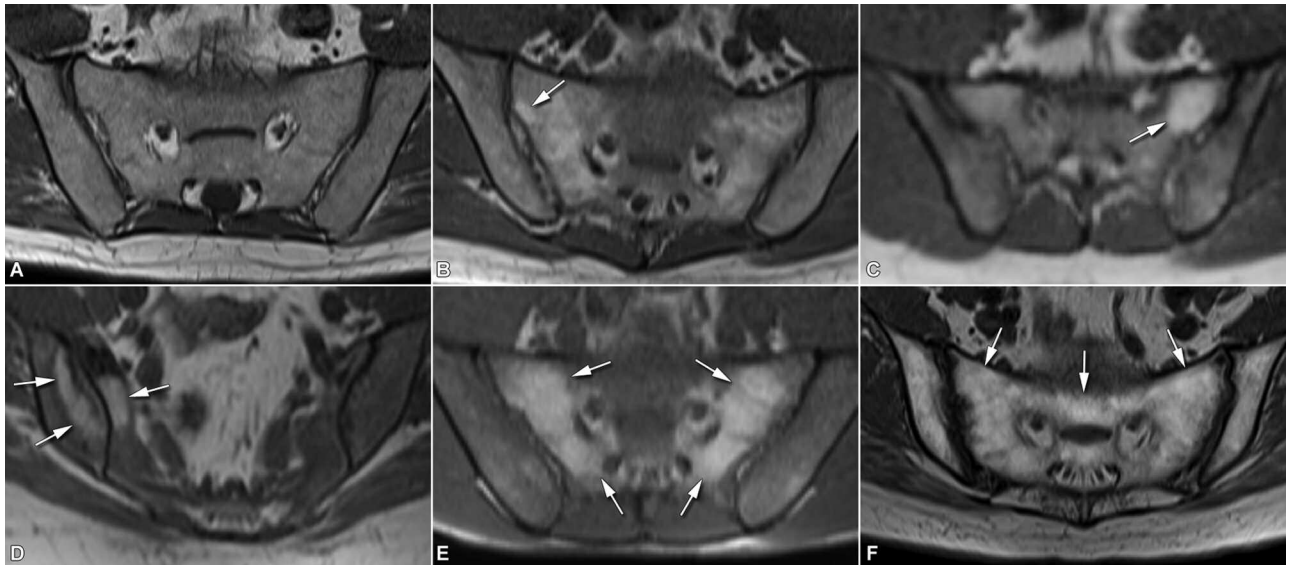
Atlas section on fat deposition. T1-weighted axial MR images from the patient population. A. Normal bone marrow signal (score = 0). B. Focal fat metaplasia (score = 1). C. Patchy fat metaplasia (score = 2). D. Band-like fat metaplasia (score = 3). E. Extensive subtotal fat metaplasia (e.g., excluding interforaminal region of sacrum; score = 4). F. Extensive fat metaplasia (score = 5). MR: magnetic resonance.
